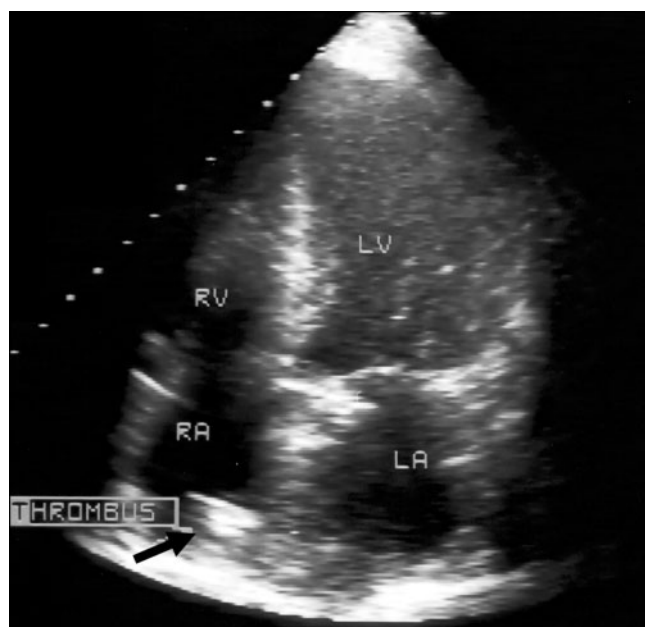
Apical four-chamber view from a two-dimensional transthoracic echocardiogram. A highly echogenic focus arising from the right atrial wall is present (arrow), separate from the tricuspid valve and interatrial septum. Definitive diagnosis of an air-filled thrombus is not possible without foreknowledge of the CT findings (see Figure 1), as a calcified mass can have similar sonographic appearances. RA, right atrium; LA, left atrium; RV, right ventricle; LV, left ventricle.
